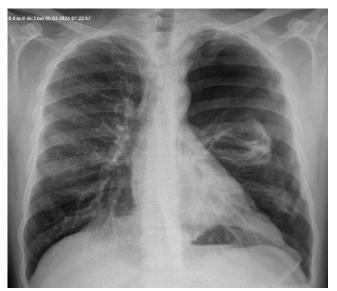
Posteroanterior (PA) chest radiograph showing left-sided pneumothorax
